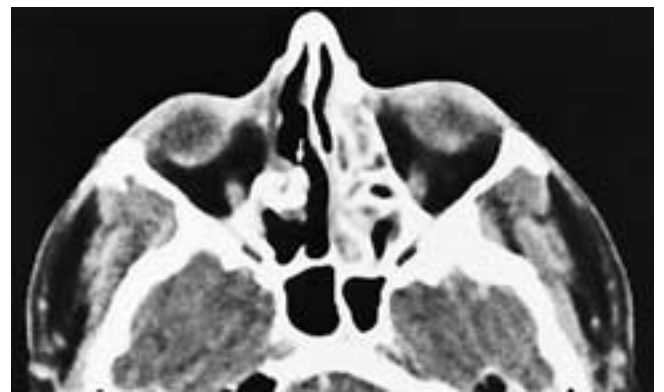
Axial CT scan shows a patient who has had a right ethmoidectomy. There is a focal area of bone production within the postoperative cavity (*arrow*). This represents reactive bone in response to surgery occurring in residual septae. It has no pathologic significance.
